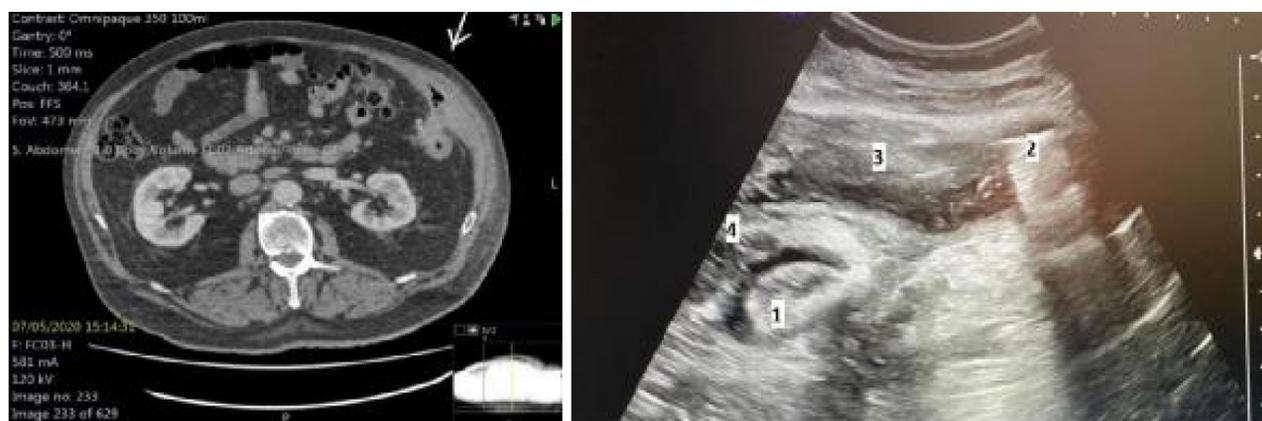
Left: CT scan description of the peritumoral abscess (arrow) in the abdominal wall; Right: intraoperative ultrasound scan (IUS), 1 - descending colon, 2 - 11th rib, 3 - intramuscular abdominal wall abscess cavity, 4 - extra-muscular tumor extension.
